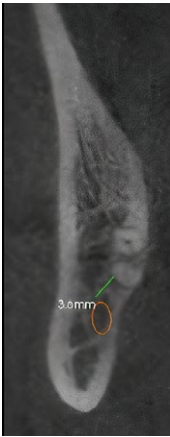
The transaxial section in CBCT shows IDC in the inferior buccal position to the root apex without contact, a distance of 3.6 mm
